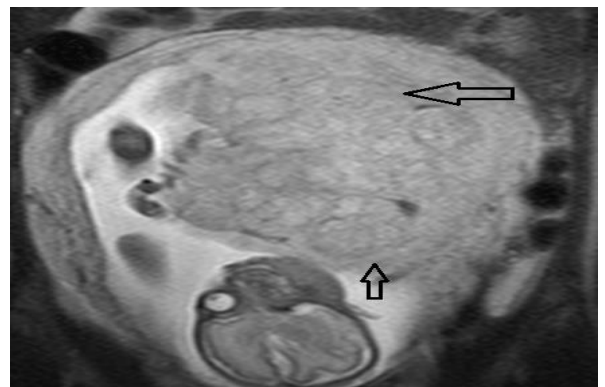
Coronal T2W MRI image of the uterus of a mother with Category A IUGR foetus reveals thick globoid shaped placenta. Baby died postnatal
